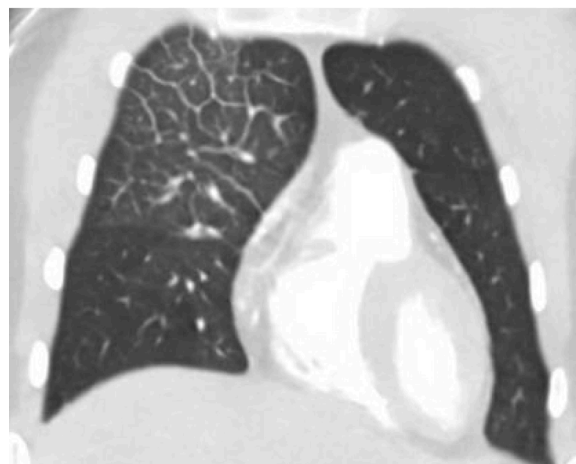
89 yo M hx admitted for fatigue and dyspnea on exertion, found to have severe mitral valve prolapse. CT chest demonstrating right upper.
